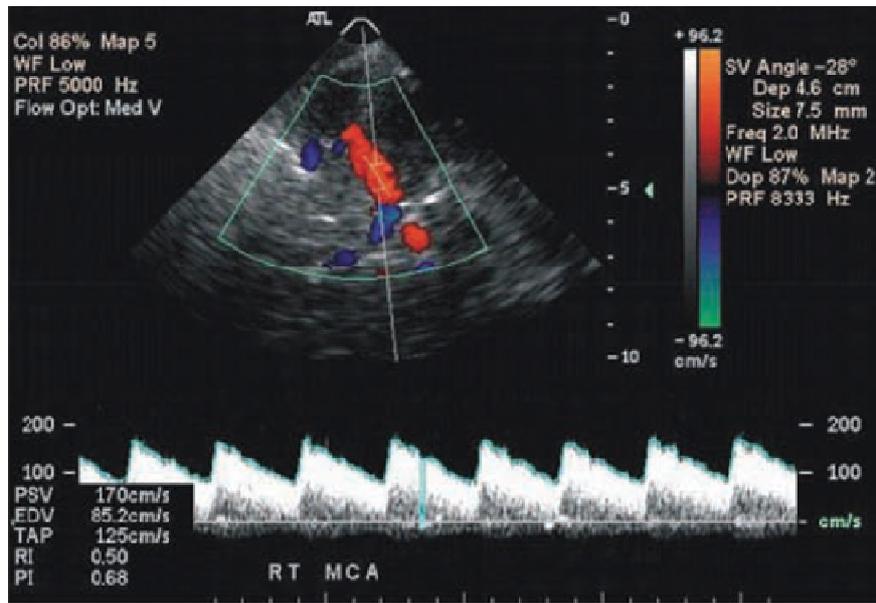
A screen shot of transcranial color-coded duplex ultrasonography. The waveform represents middle cerebral artery blood flow velocity.
